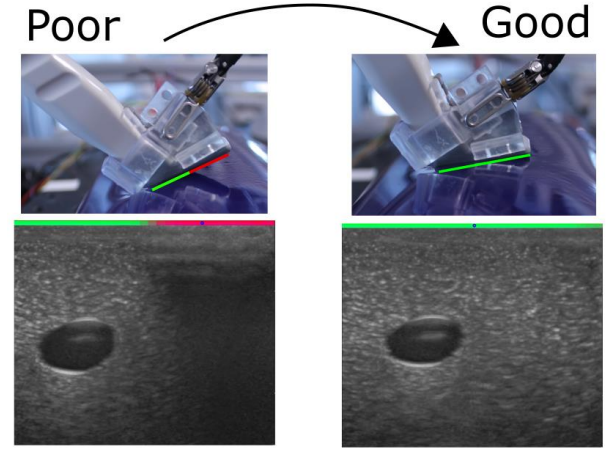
Coupling quality estimation between ultrasound probe and tissue surface with subsequent adaption of the ultrasound probe from poor coupling (left) to good coupling (right)
